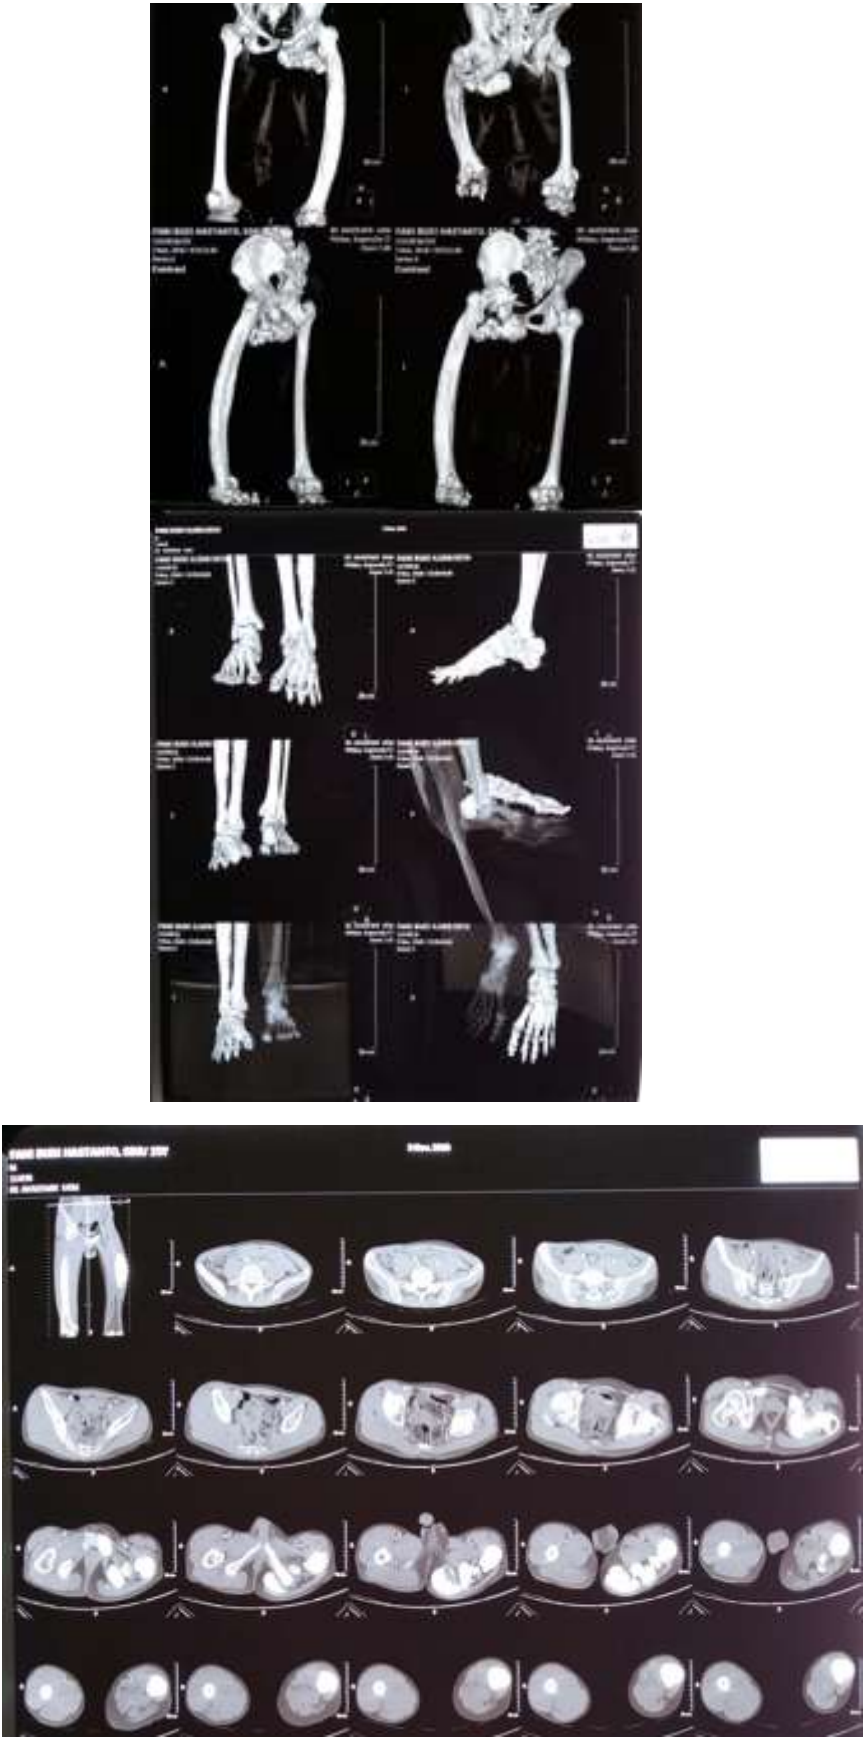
CT scan of lower extremity
